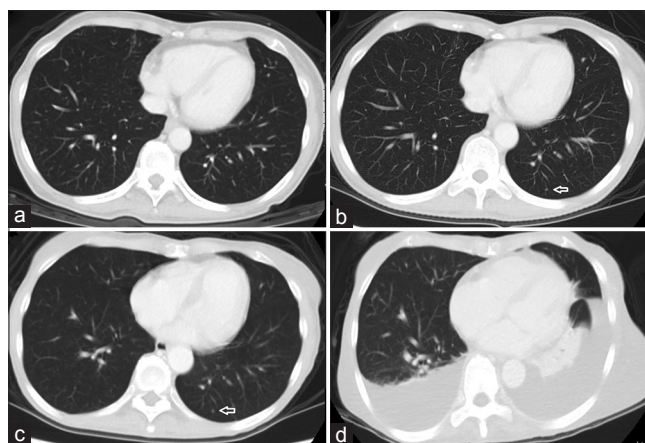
Computed tomography showing (a) no lung metastasis 12 months before nivolumab treatment; (b) a small lung metastasis (arrow) 6 months before nivolumab treatment; (c) a stable lung metastasis (arrow) before nivolumab treatment; (d) massive pleural effusion 3 weeks following the second dose of nivolumab
